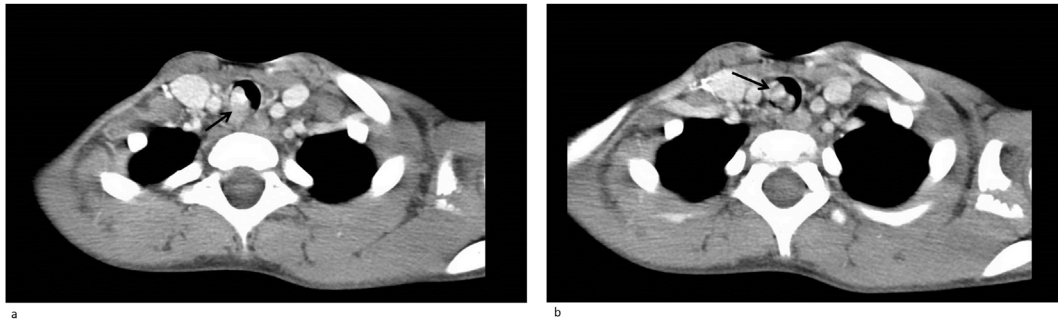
Axial CT contrast neck indicating tumor arising from membranous trachea with intraluminal exophytic and extratracheal components.
